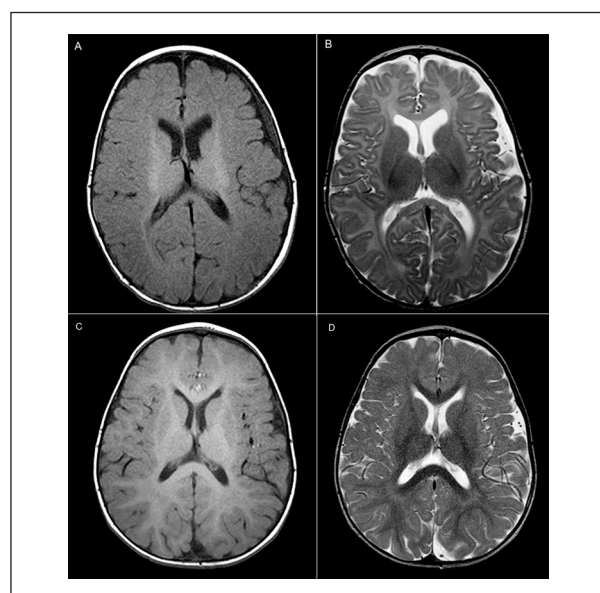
Magnetic resonance imaging scans of the brain (patient 6)
